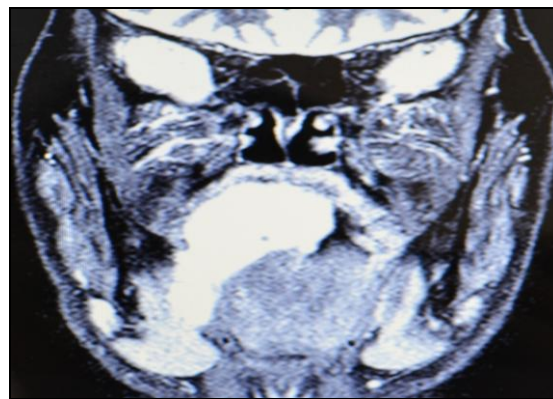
MRI REVEALED A WELL DEFINED LARGE LOBULATED HOMOGENOUS MASS IN THE RIGHT HALF OF THE TONGUE WHICH APPEARS HYPERINTENSE ON T2W
